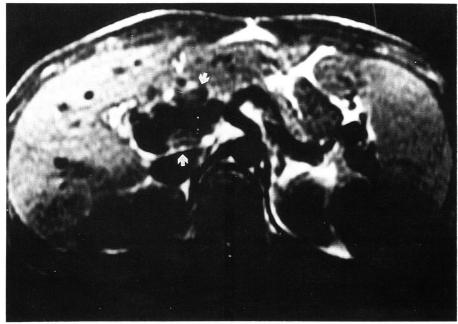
A T1-weighted MRI scan of the abdomen showing enlarged periportal lymph node(arrow), periportal collateral formation, and splenomegaly.
